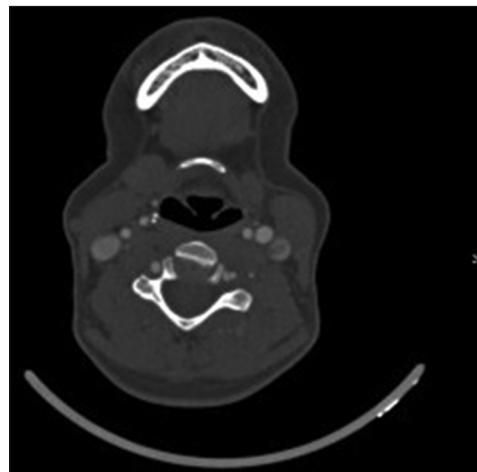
The left vertebral artery fenestration on computed tomography axial scan.
